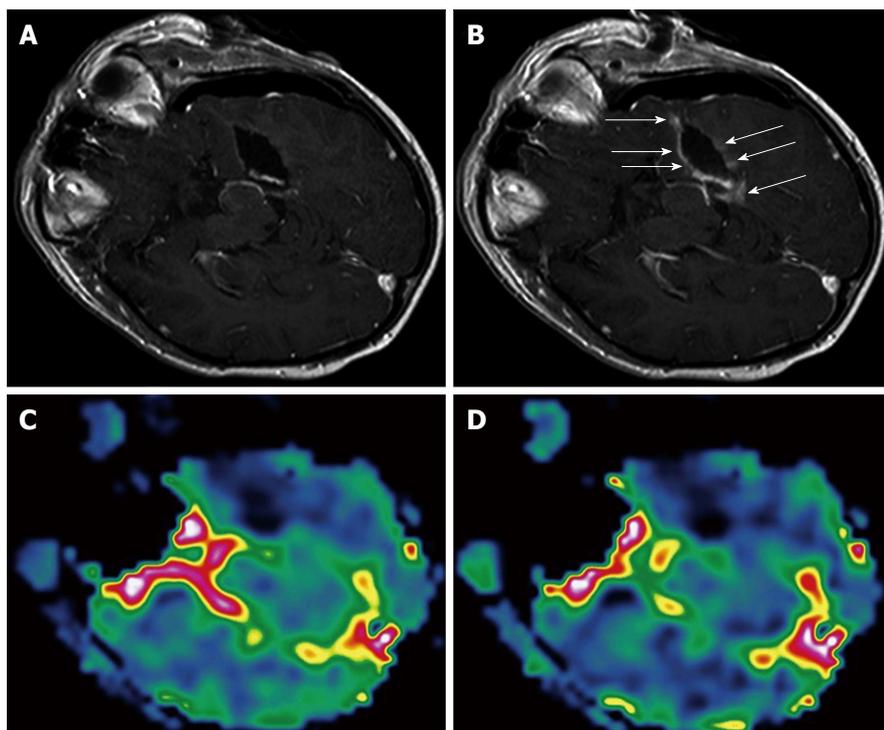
Surgically induced intraoperative contrast leakage. Reprinted from *NeuroImage* with permission^[9]. A: T1-weighted magnetic resonance (MR) image of the initial resection control. Residual tumor was depicted (not shown), neuronavigation was updated and the residual tumor was removed; B: T1-weighted MR image in identical orientation as in (A) of the second intraoperative resection control. At the border of the resection cavity there is contrast enhancement of previously non-enhancing tissue (arrows), which is caused by the neurosurgical resection leading to a leakage phenomenon. Perfusion maps of rCBV (C) and rCBF (D) at the second resection control demonstrate no elevated values in areas of contrast enhancement but complete resection of the tumor. rCBV: Regional cerebral blood volume; rCBF: Regional cerebral blood flow.
